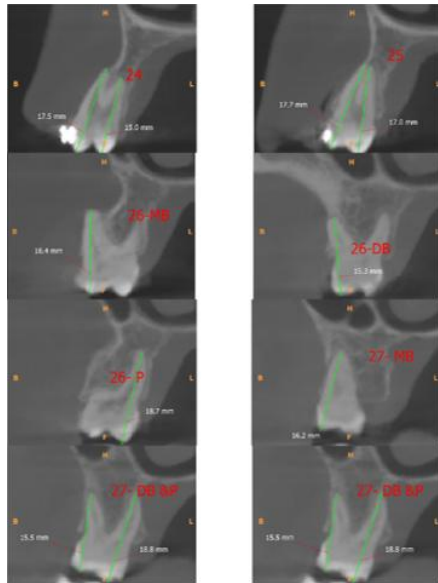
Pre-treatment CBCT for root length measured along long axis of tooth in sagittal section
